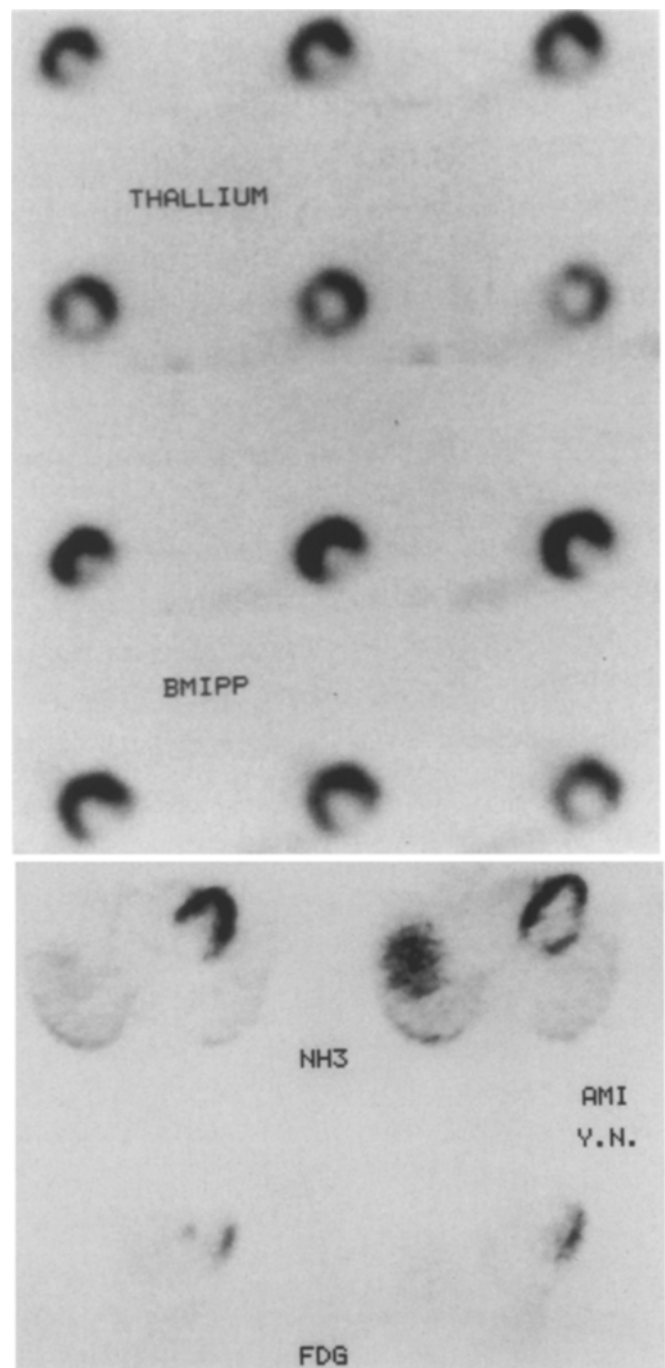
Example of resting studies in a patient with acute inferior wall myocardial infarction, comparing regional distribution of [^{123}I]BMIPP, ^{201}Tl , [^{13}N]ammonia, and 2-FDG. (Courtesy of N. Tamaki, M.D., Department of Nuclear Medicine, Kyoto University Hospital, Kyoto, Japan)
